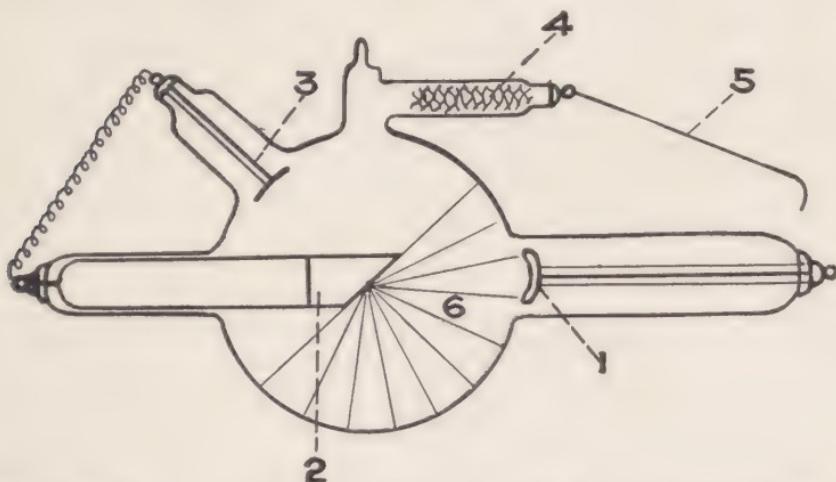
Modern type of roentgen-ray or focus tube. 1, cathode; 2, target; 3, accessory anode; 4, vacuum regulator; 5, adjustable wire; 6, X-ray hemisphere.
